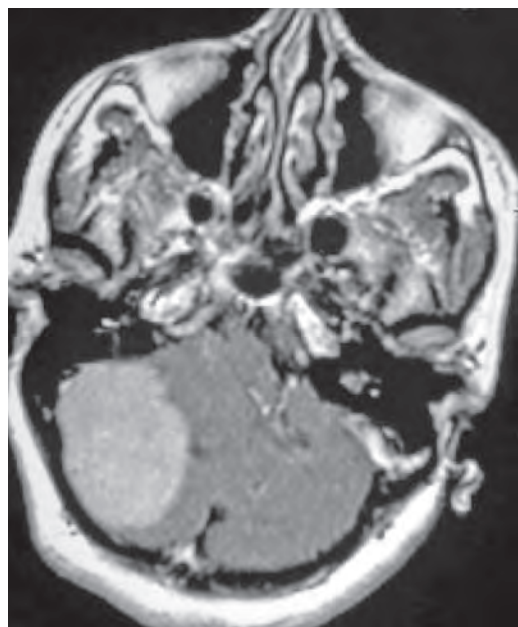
Contrast enhanced axial MR image showing a lateral tentorial leaf meningioma with a predominately infratentorial component. This lesion was approached using a lateral suboccipital craniectomy and an infratentorial supracerebellar approach
